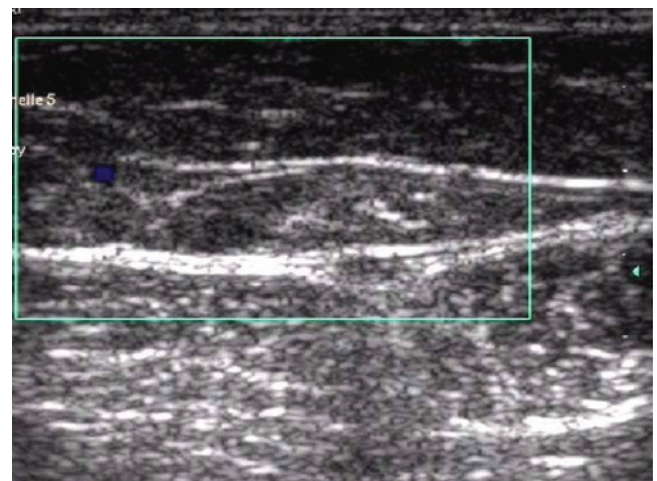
Evidence of a noncompressible GSV with thickened walls and absence of flow on color ultrasound analysis are signs of successful obliteration. (Adapted from Pichot O, *Atlas of Ultrasound Images*, Copyright VNUS® Closure)
